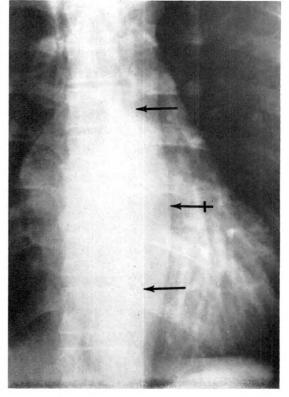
A normal supine anteroposterior overexposed grid roentgenogram. The left paravertebral line (←) and aorta (←) are in normal relationship.
